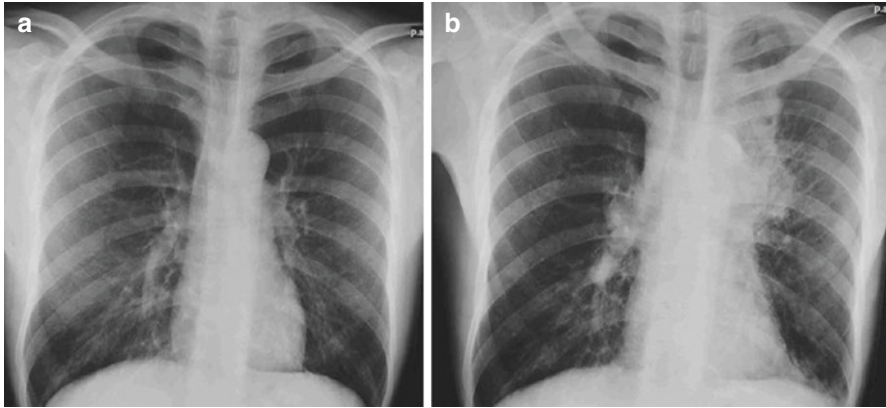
Paradoxical IRIS following initiation of antiretroviral therapy. Panel A—Normal Baseline chest radiograph at start of treatment for cervical lymph node TB in newly diagnosed PLWHIV with blood CD4 count 230 cells/ μ L. Patient commences antiretroviral therapy one week later. Panel B—Chest radiograph (CXR) at week 3 following onset of new cough, fever and malaise for 4 days. CXR shows increased upper mediastinal widening and left upper zone consolidation consistent with lymphadenopathy and parenchymal changes. Investigation revealed no other disease process, drug sensitive lymph node TB and the symptoms and signs resolved during investigation with no need for specific further treatment
